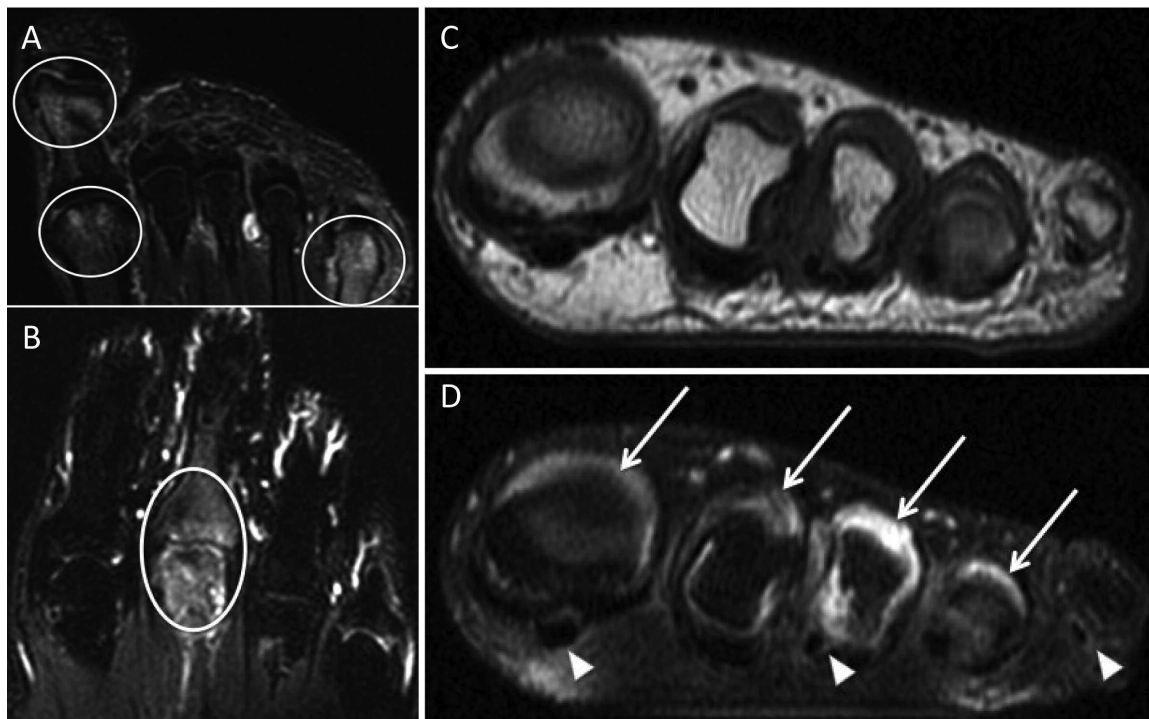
Panels A and B are coronal short-tau inversion recovery images of the foot (A) and hand (B), showing bone marrow edema in the first and fifth metatarsophalangeal (MTP) and first interphalangeal joint of the foot (A) and the third metacarpophalangeal joint of the hand (B). Panels C and D are axial T1-weighted precontrast and fat-suppressed postcontrast sequences of the MTP joints of the foot. The fat-suppressed postcontrast image (D) shows synovitis (arrows) in the first to fourth MTP joints and mild flexor tenosynovitis (arrowheads) at the first, third, and fifth MTP joint.
